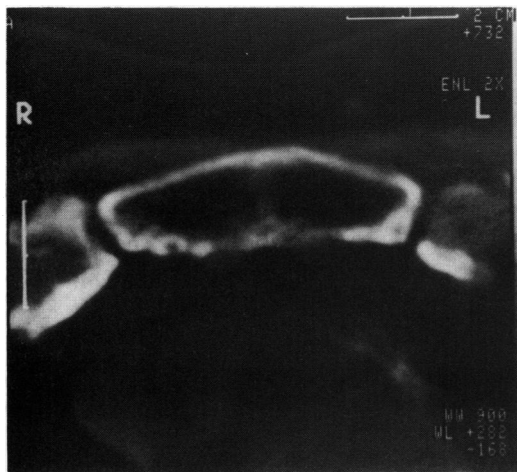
Computed tomography scan of the sternoclavicular joint showing erosion of the chondrosternal articular surfaces and posterior surface of the sternum.
